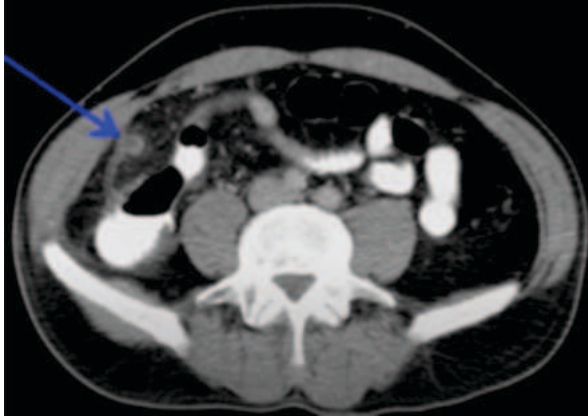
CT Image Showing Appendicitis
